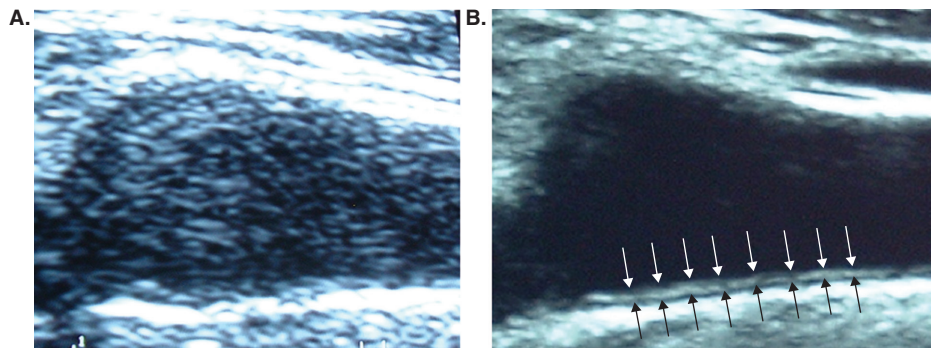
Comparison of ultrasound device sensitivity. The right carotid artery bulb in longitudinal view taken with two different ultrasound instruments over a half-hour period from the same individual (RAH). A. The image captured by the Acuson Aspen ultrasound device with the L7 transducer, comparable to the technology reported in the ENHANCE study [91]. B. The same region scanned by the Phillips model HD11 XE with the L12-5 transducer. The arrows indicate the anterior and posterior limits of 8 individual carotid intima-medial thickness (cIMT) measurements (mean ~ 0.55 mm) acquired over ~ 1 cm interval of the posterior wall of the carotid bulb. The same extent of cIMT is much more difficult to visualize with the technology used in the ENHANCE study (A).
